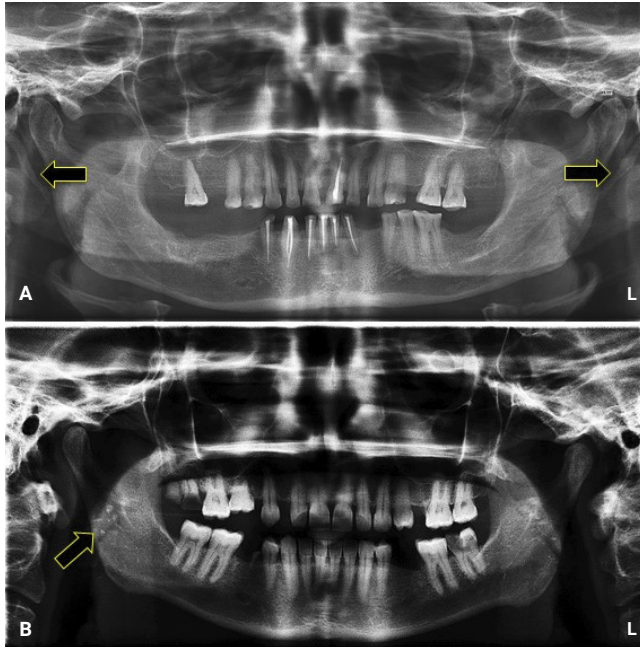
(A) The arrows on the panoramic radiograph depicting calcified stylohyoid ligament bilaterally. (B) The arrow on the panoramic radiograph showing multiple radiopaque masses superimposed on the right mid-ramus region suggestive of tonsilloliths (The contrast of the radiograph is altered for better visualisation of the calcification).
